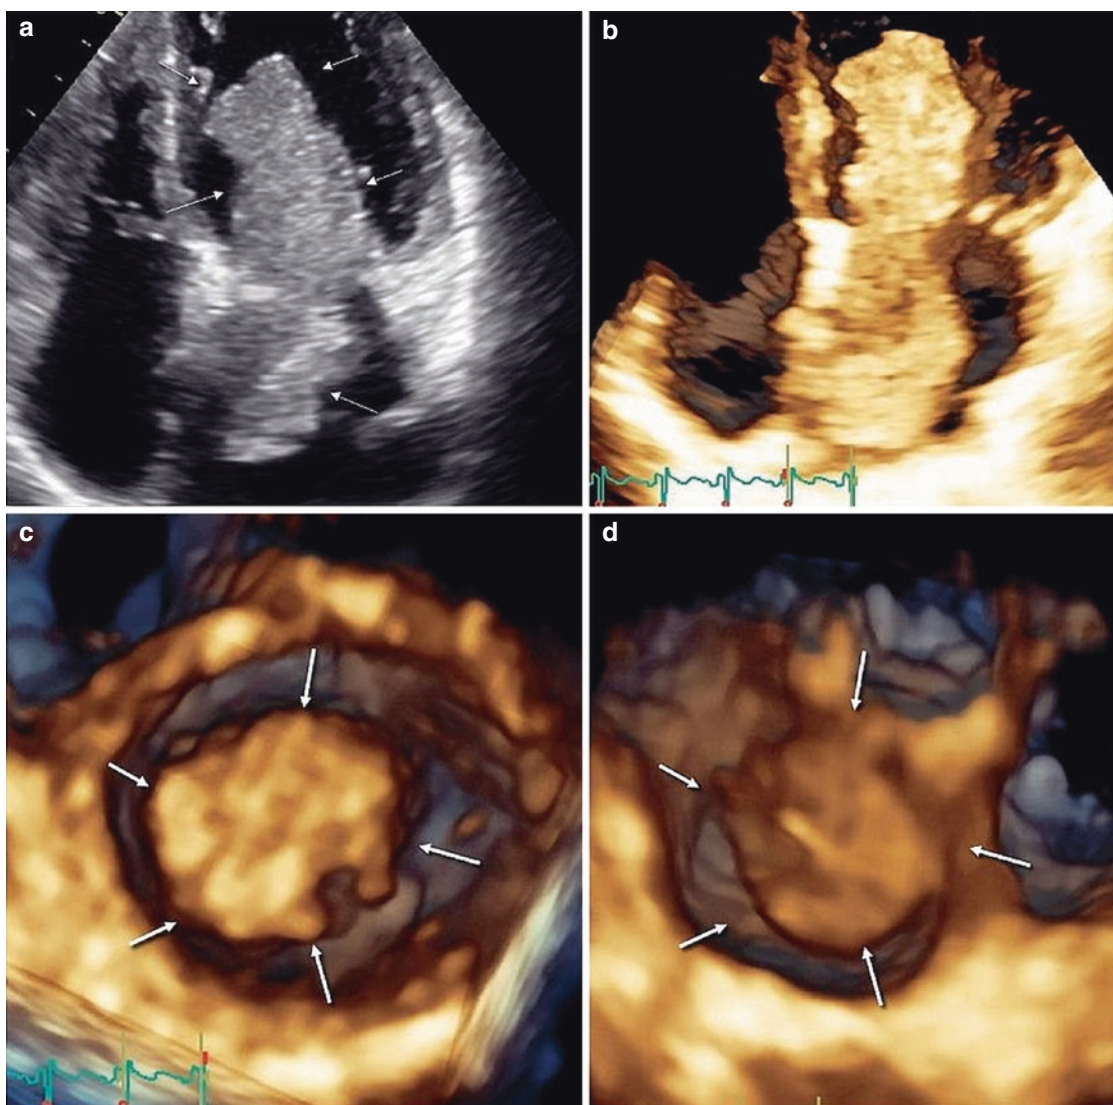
Various display modes of cardiac masses (left atrial myxoma) imaged by three-dimensional echocardiography. (a) Volume rendering (Video 24.1a). (b) Color volume rendering (Video 24.1b). (c) Multiplane (biplane) (Video 24.1c). (d) Surface rendering. See text for details
